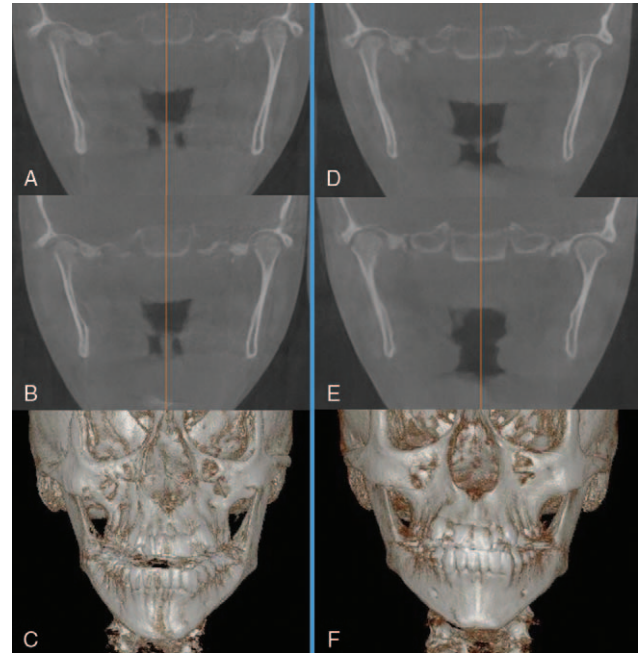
CBCT image showing left condylar enlargement in the coronal view. A, Anterior image; B, posterior image; C, three-dimensional craniofacial reconstruction. CBCT image showing symmetry between left and right condyles in the coronal view. A, Anterior image; B, posterior image; C, three-dimensional craniofacial reconstruction.
